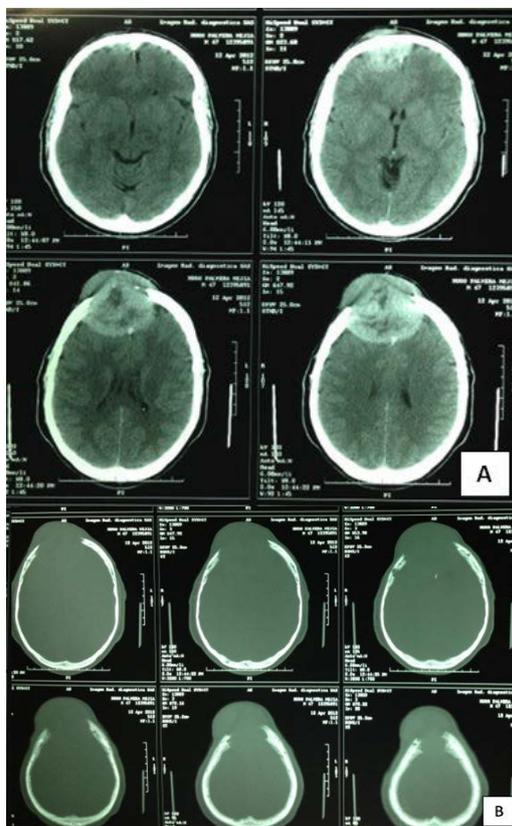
Head CT-scan, A. axial slides showing a large, circular lesion located on the frontal pole, compromising frontal hemispheres bilaterally, but also the frontal bone, protruding through it, and bulking the scalp. B. Bone window, showing the large bone defect caused by the tumor
